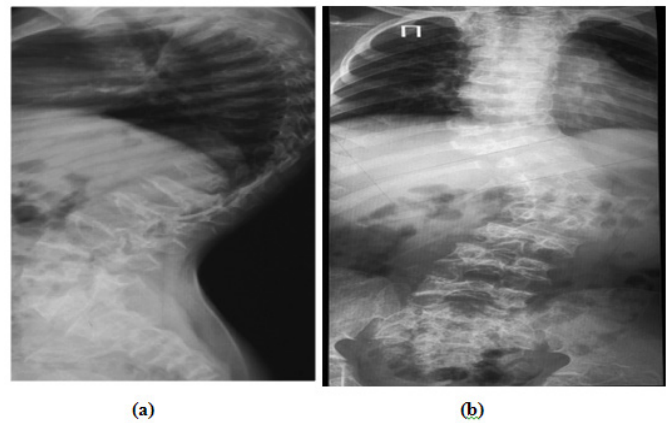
a) Lateral spine radiograph of a -13-year-old-girl with the diagnosis of SMD type Kozlowski showed evident generalized platyspondyly with anterior wedging. b) Note, severe kyphoscoliosis deformity. (kyphosis - 70° Cobb and scoliosis - 55° Cobb)(Preoperative radiographs).
